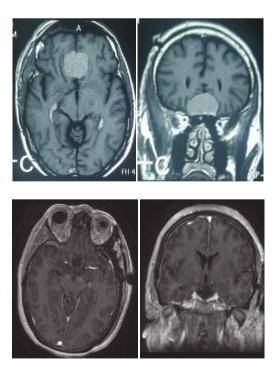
A pre and post-operative MRI axial and coronal cuts of a case of Tuberculum sellae meningioma showing complete excision.
